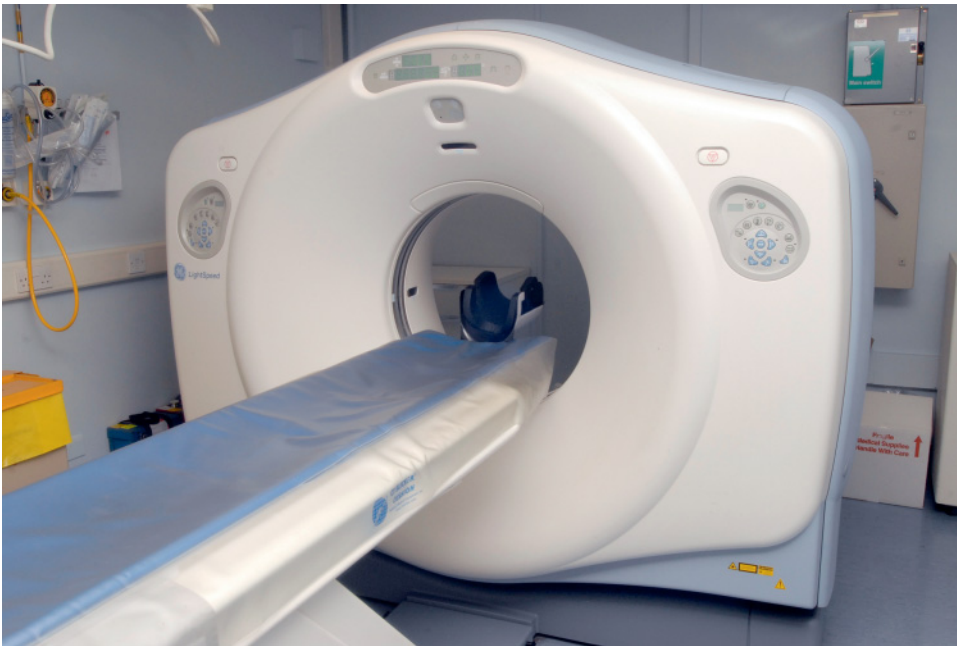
An example of a modern computed tomography scanner, showing the table, head support, and gantry. (With permission from Cardiff University, UK.)
